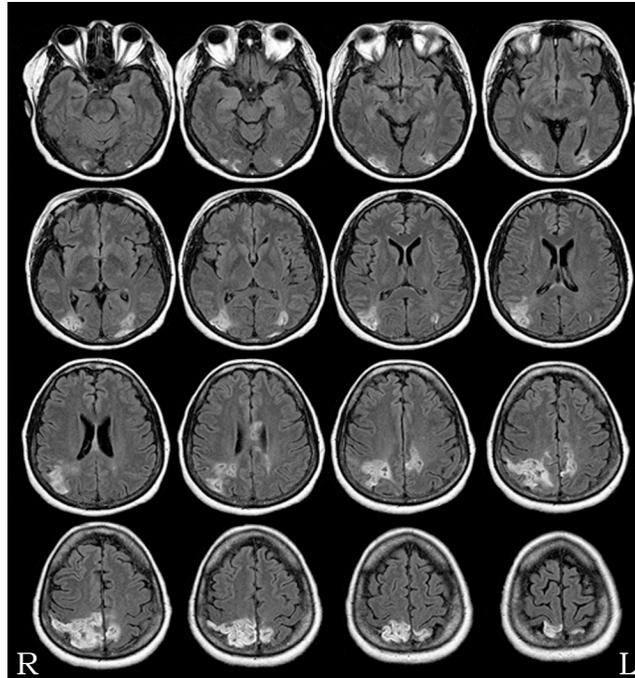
Axial FLAIR sequences of MRI scans of patient SL within 1 month of testing. White areas indicate hypertense signal in damaged brain regions. R = Right, L = Left side of the brain
